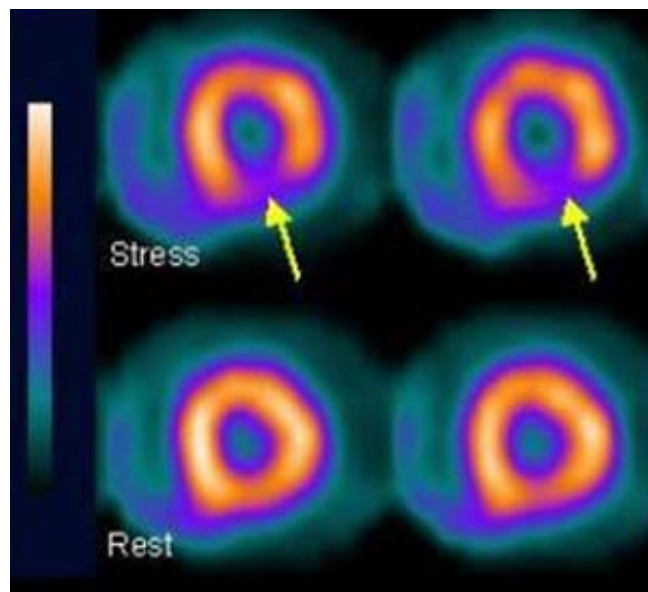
SPECT imaging [12]. (The upper row shows short-axis slices after stress condition and the lower row shows the same slices when the body is at rest. Arrows indicate an ischemic region of the heart wall).
